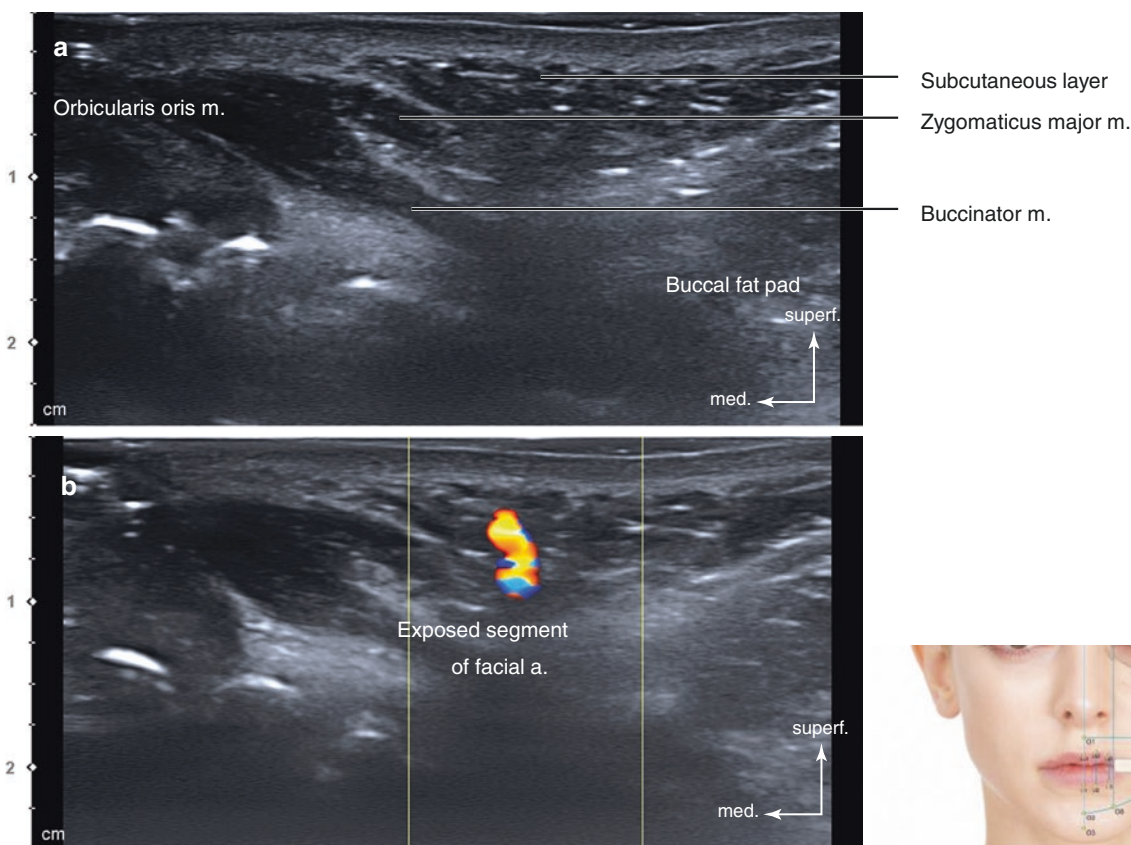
Ultrasonography of the point at 1.5 cm lateral to the cheilion (O6). (a) B mode (transverse view, 15 MHz by linear transducer), (b) Doppler mode (transverse view, 15 MHz by linear transducer), (c) B
